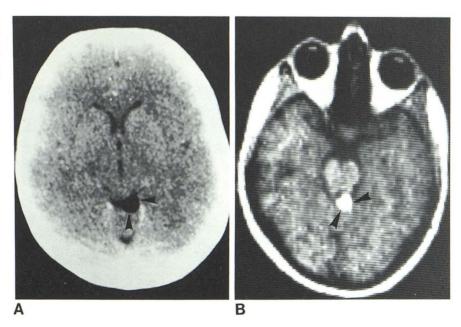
Lipoma of tectum of mesencephalon, 20year-old woman with headaches. A, Contrast-enhanced transverse CT scan. Low-density region (*arrowheads*) in tectum of mesencephalon. B, Transverse NMR scan. Area of high signal intensity (*arrowheads*) in tectum of mesencephalon. Signal intensity is similar to that found in orbital and facial fat.
